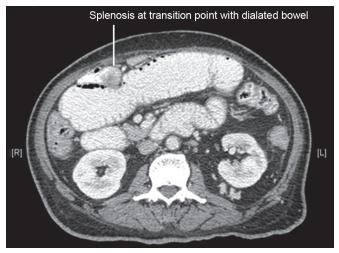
Contrast-enhanced computed tomography of the abdomen suggesting splenosis with transition point of intestinal obstruction
